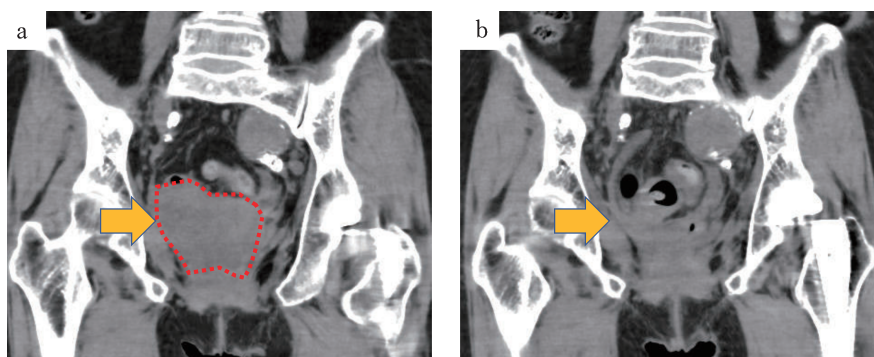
CT scan before and after pembrolizumab administration
